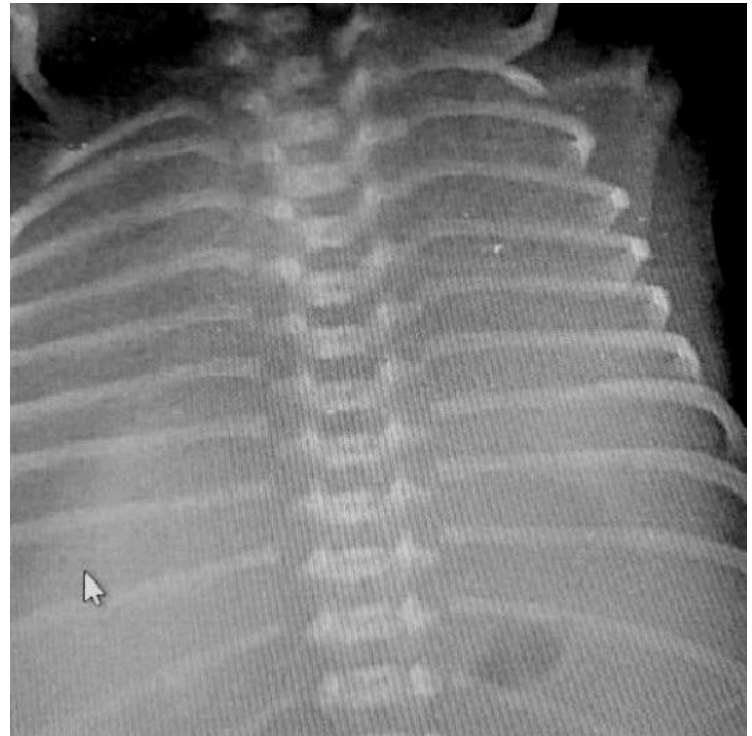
Thoracic Ectopia Cordis with cardiac anomalies - Postnatal chest radiograph, anteroposterior view, revealing complete absence of the sternum associated with vertically oriented clavicles and widened interclavicular space.
